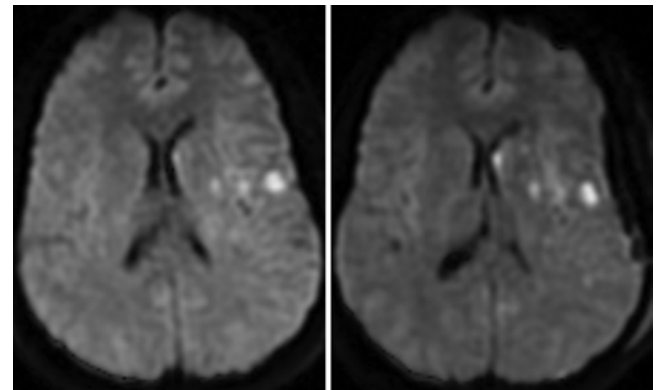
Case 2. Preoperative (*left*) axial diffusion weighted MR image revealing limited ischemic injury, which is essentially unchanged on a comparable image obtained postoperatively (*right*).
